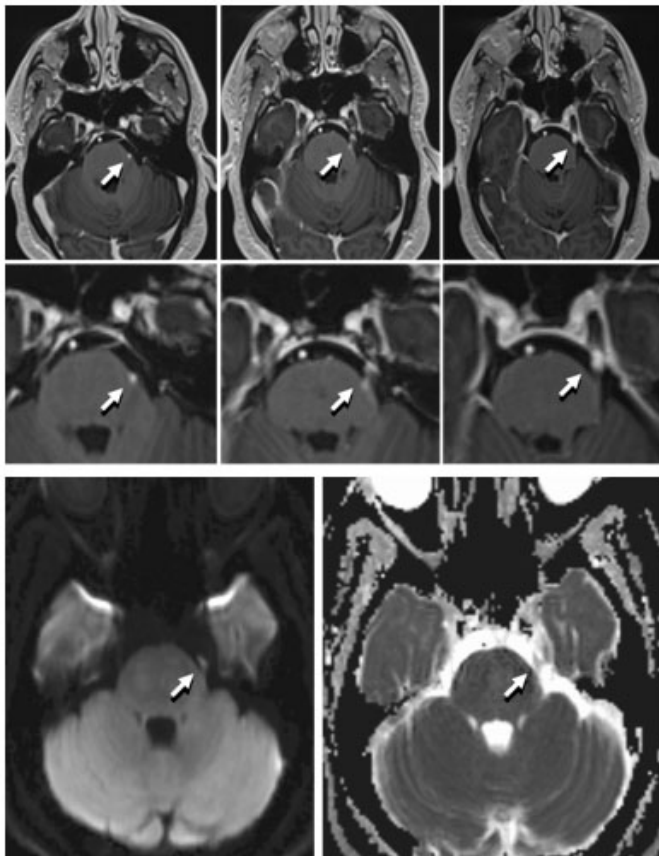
Upper panel—Postcontrast axial brain MRI images demonstrating abnormal increased enhancement of left trigeminal nerve at root entry zone (REZ), cisternal segment and extension of the abnormal enhancement to the Gasserian ganglion. The lower panel demonstrated the same in 5× magnification. Bottom row—Diffusion weighted imaging (DWI) and apparent diffusion coefficient (ADC) map axial brain MRI images demonstrating abnormal increased enhancement of left trigeminal nerve at root entry zone (REZ), cisternal segment, and extension of the abnormal enhancement to the Gasserian ganglion. The lower row demonstrated the same in 5× magnification.
